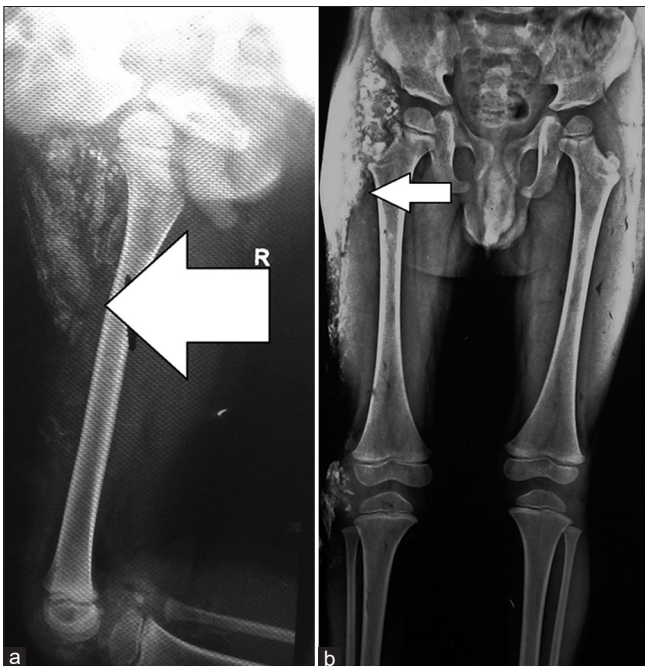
(a): X-ray of right lower limb (lateral view) showing reticular pattern of ectopic bone formation in dermis and subcutis. (b): X-ray both lower limbs (anteroposterior view) showing ectopic bone formation in dermis and subcutis in lateral part of right thigh
